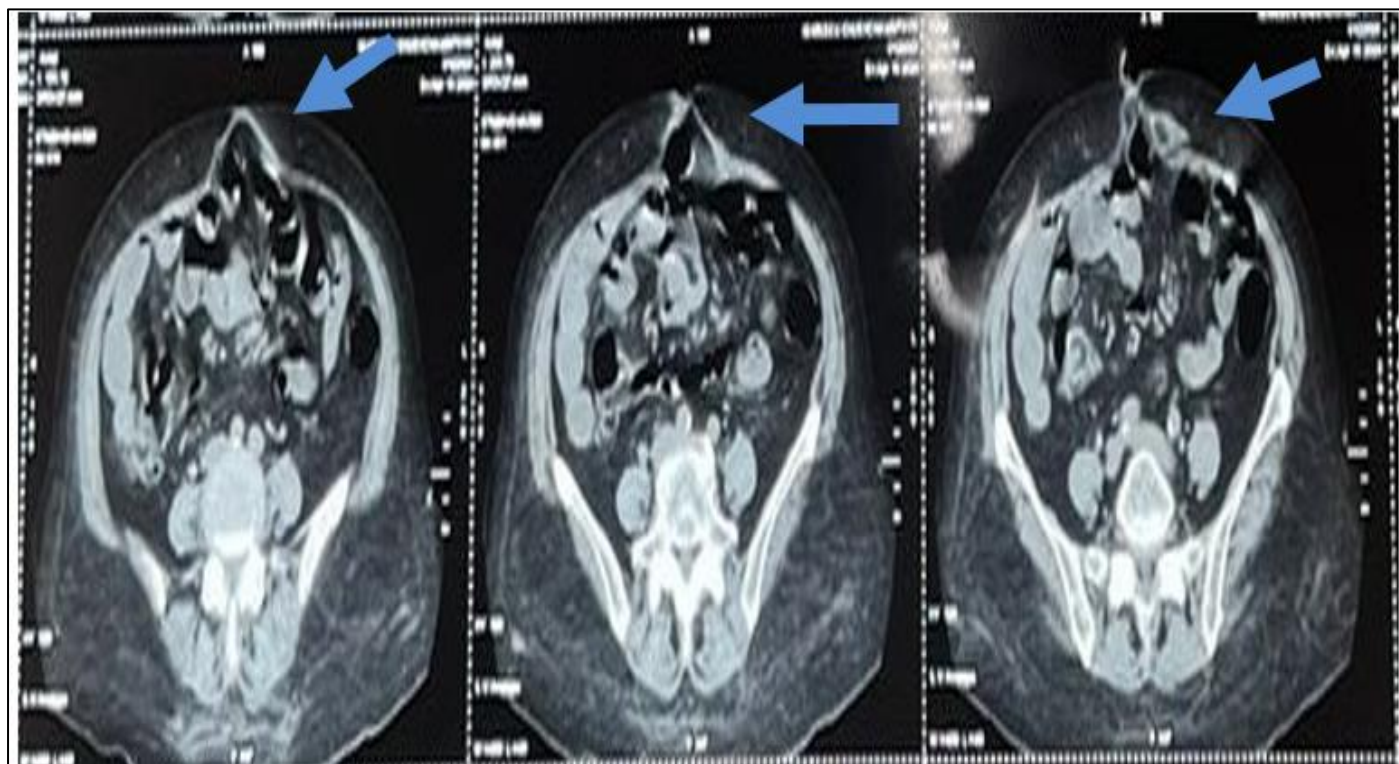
Hernial Defect as Seen on CT Scan
